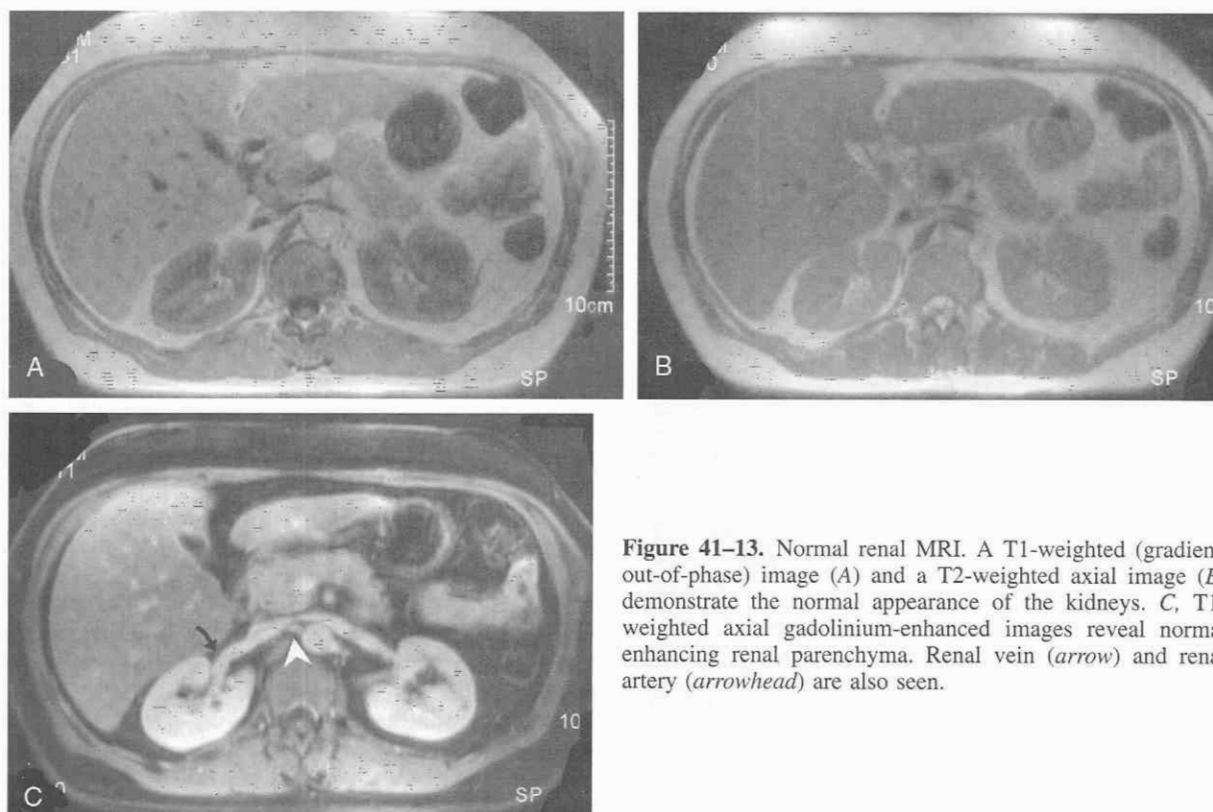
Normal renal MRI. A T1-weighted (gradient, out-of-phase) image (A) and a T2-weighted axial image (B) demonstrate the normal appearance of the kidneys. C, T1-weighted axial gadolinium-enhanced images reveal normal enhancing renal parenchyma. Renal vein (arrow) and renal artery (arrowhead) are also seen.
